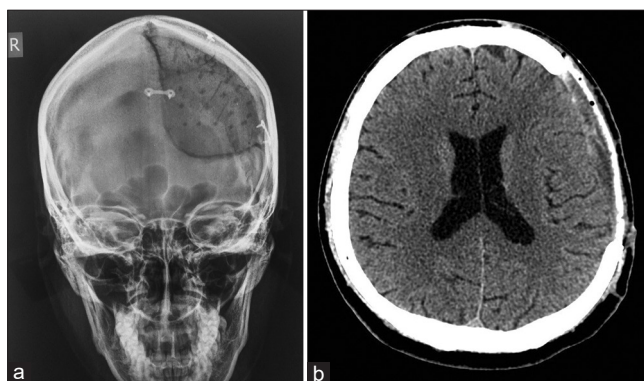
(a) Postoperative plain X-ray AP craniogram showing the implant perfectly fitted into the left frontoparietal cranial defect. (b) Postoperative axial MSCT scan of the head showing the implant perfectly fitted into the left frontoparietal cranial defect.
